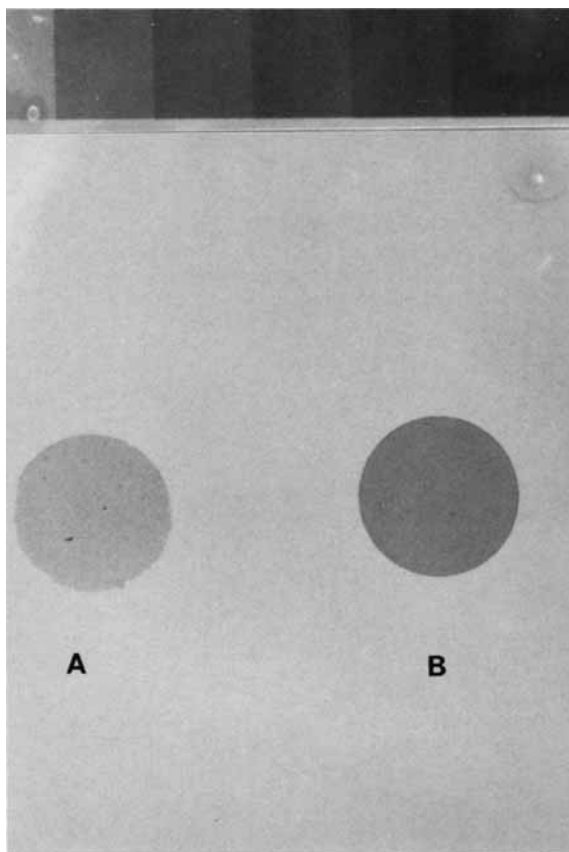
Positive radiographs of uranyl nitrate–polymannitolphosphonate (ca. 10 wt % salt) (A) and bismuth bromide–polyglycerphosphonate (ca. 15 wt % salt) (B) systems, relative to an aluminum stepwedge bar.
